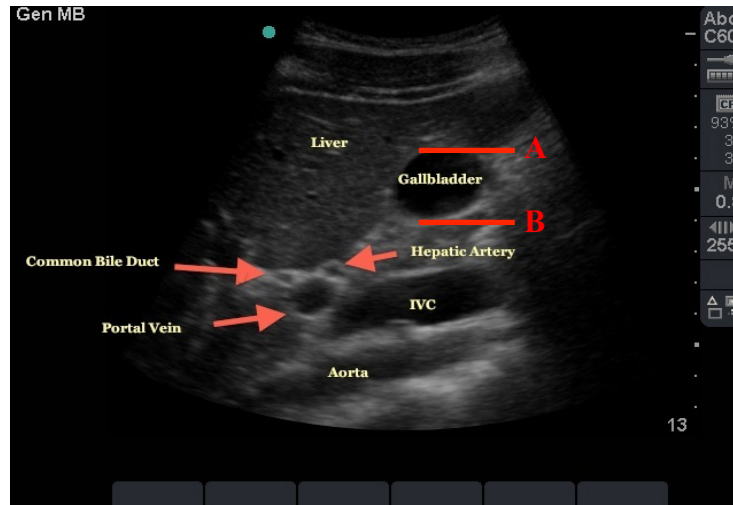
Normal ultrasound image of the abdomen showing the major structures.
